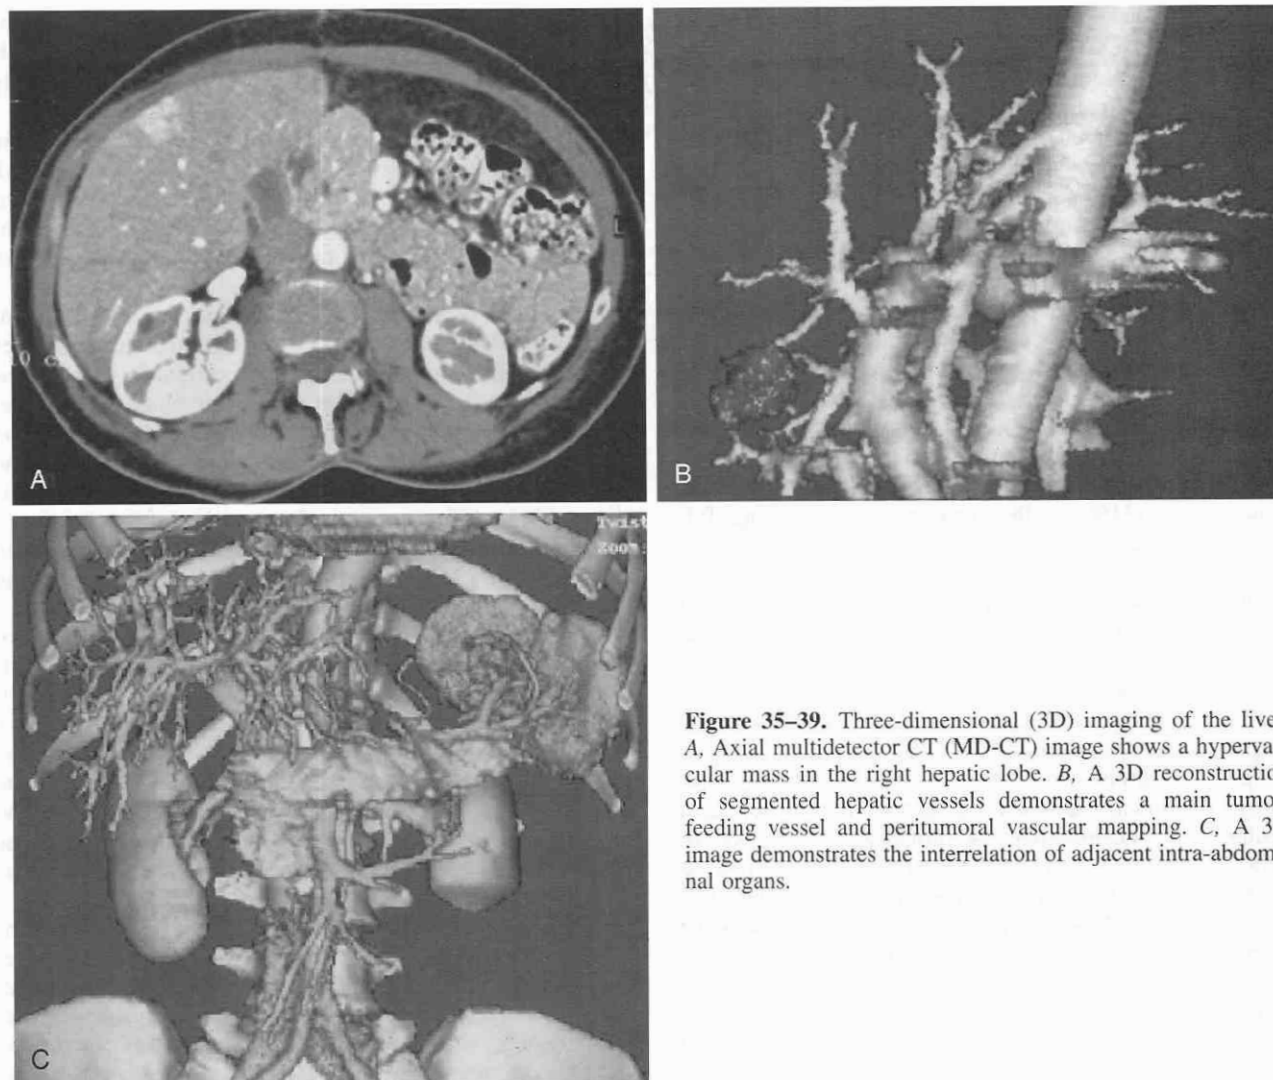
Three-dimensional (3D) imaging of the liver. *A*, Axial multidetector CT (MD-CT) image shows a hypervascular mass in the right hepatic lobe. *B*, A 3D reconstruction of segmented hepatic vessels demonstrates a main tumor-feeding vessel and peritumoral vascular mapping. *C*, A 3D image demonstrates the interrelation of adjacent intra-abdominal organs.
